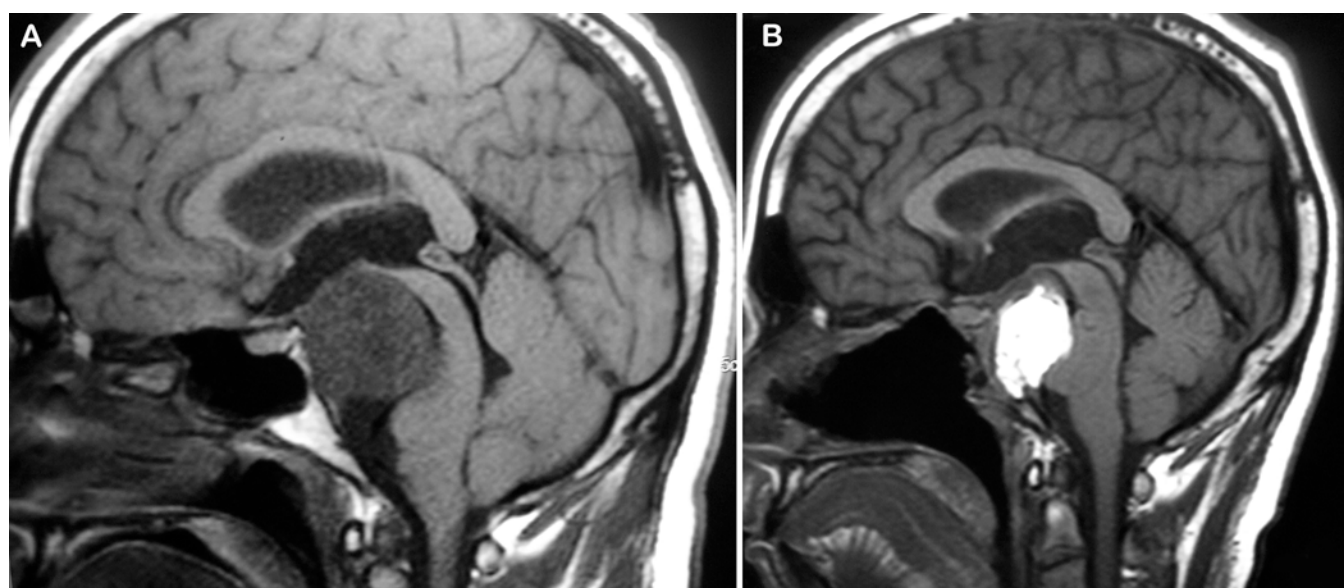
Preoperative (A) and postoperative (B) MR images demonstrating endoscopic resection of a clival chordoma with a large intradural component, possible via a large transnasal craniotomy. Fat used in the reconstruction is visible in the postoperative image.
